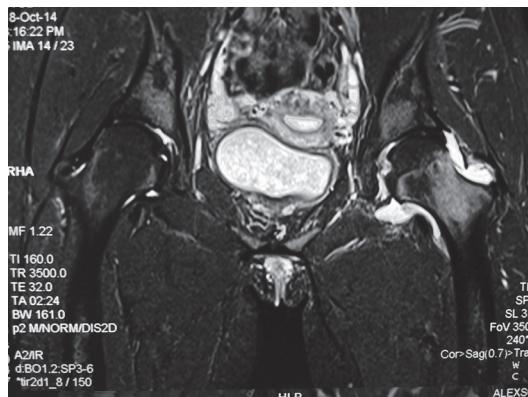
T2-weighted MRI showing a hyperintense signal in the left femoral neck extending to the femoral head, joint effusion. The extensive cartilage defect at the femoral head was not visible.
